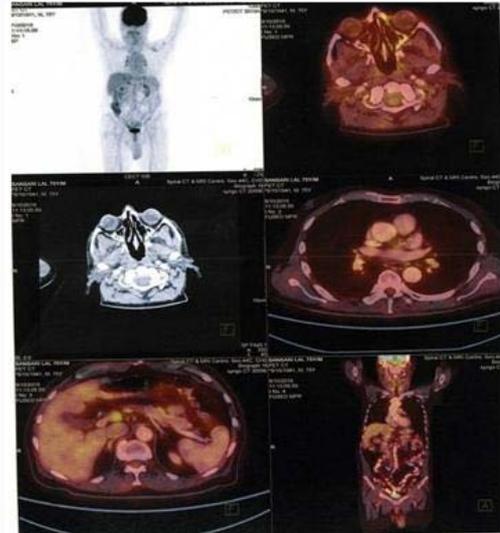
PET-CT showing complete resolution of nasopharyngeal lesion with significant reduction in FDG avidity and size of portocaval lymph node.
